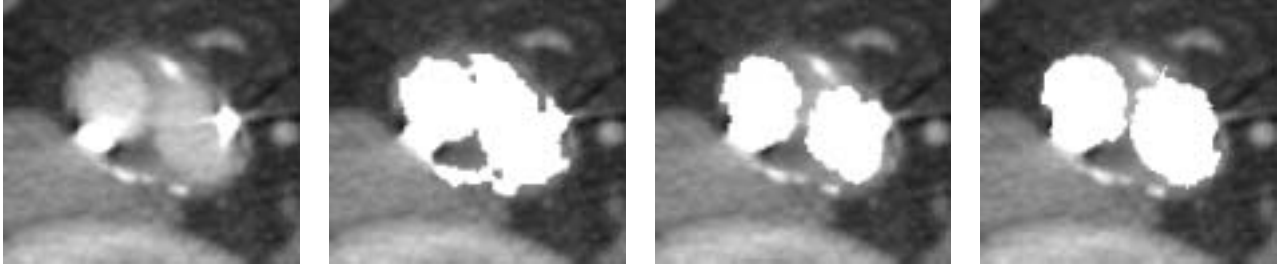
CTA slice of patient II (left), segmented by region growing under expert guidance (second), the slice-based approach (third) and the approach orthogonal to the graft axis (last).
